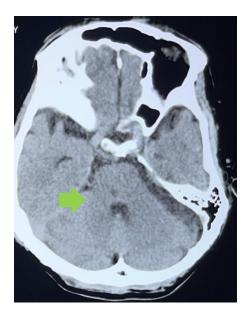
The CT Scan showed old lacunar infarction in the brain stem
